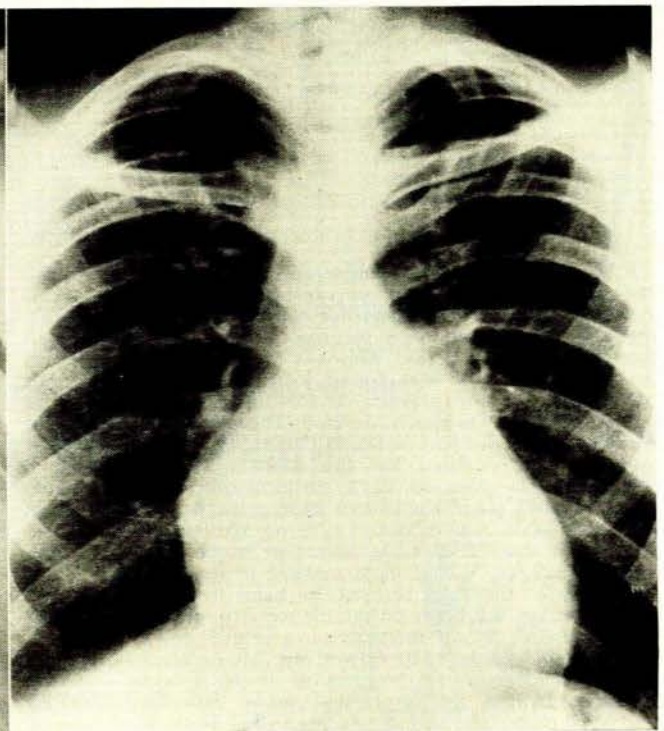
PA radiograph of chest showing marked decrease in heart size after 1 month's therapy (Patient 9).
